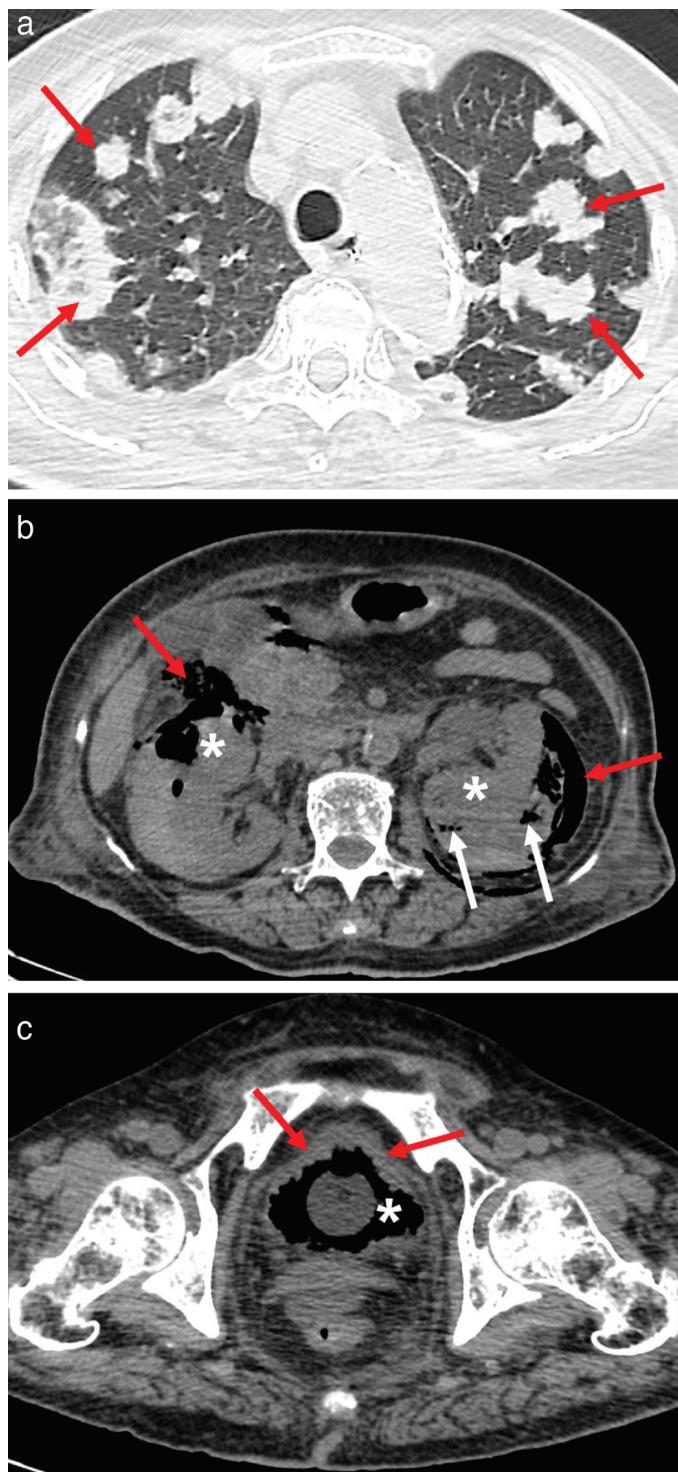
Chest and abdominal CT findings.
